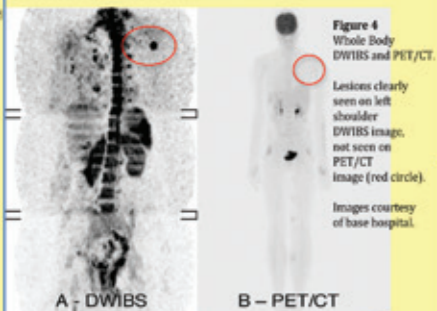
Whole Body DWI and PET/CT. Lesions clearly seen on left shoulder DWI image, not seen on PET/CT image (red circle). Images courtesy of base hospital.
